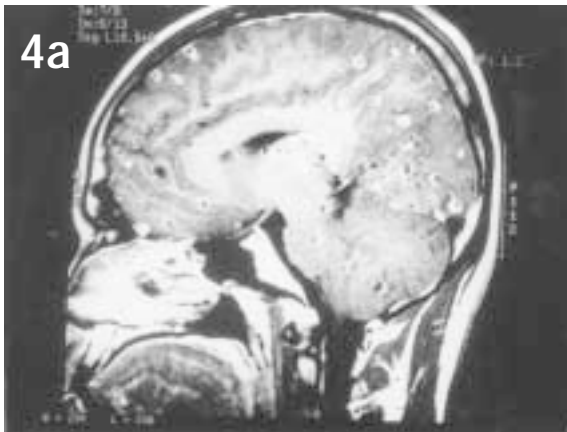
T₁ weighted, post contrast sagittal, axial and coronal MR images reveal nodular hyperintense ring enhancing lesions around the hypointense areas.
